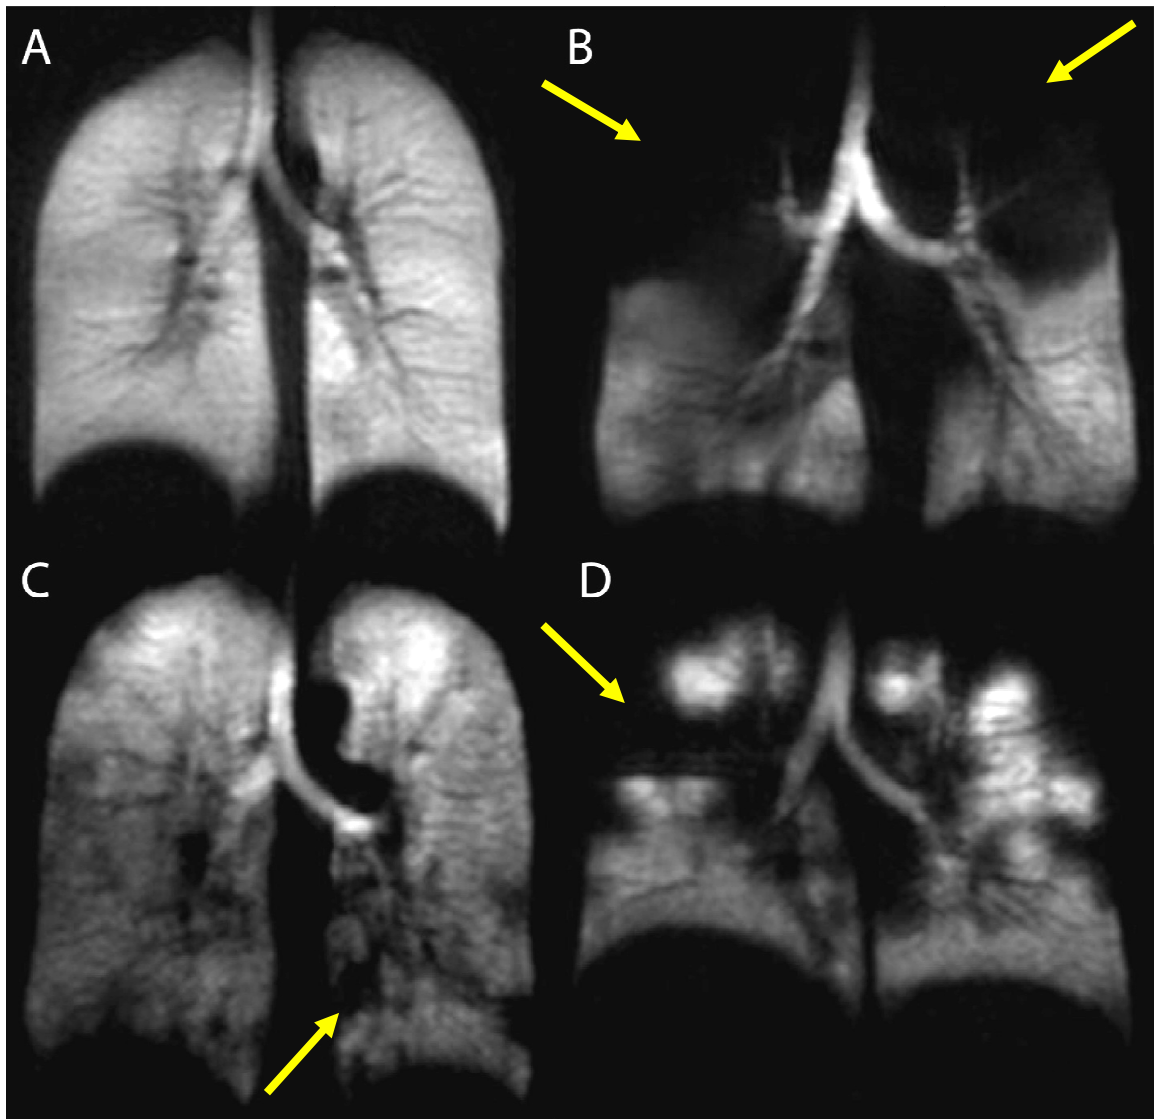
Hyperpolarized ^3He MRI images
